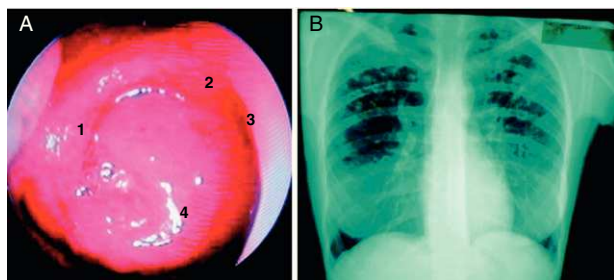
(A) Image of a tumor mass in the rhinopharynx taken with nasal endoscopy: (1) Tubaric ring; (2) Choanal arch; (3) rear edge of the nasal septum; (4) TB pseudotumor. (B) Chest radiography: bronchogenic dissemination lesions in both upper lobes that coexist with miliary dissemination.
